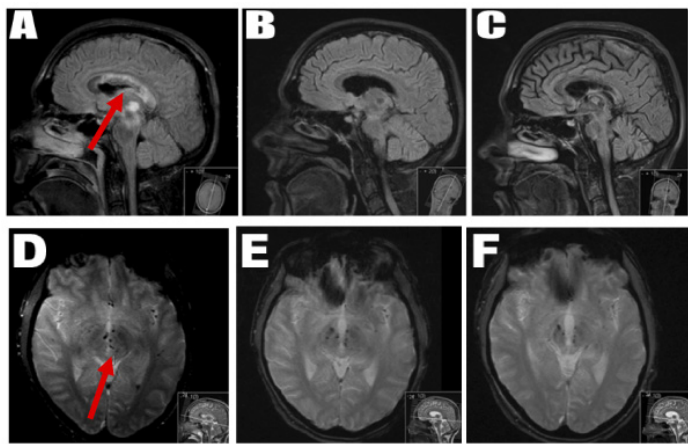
Figure A-C show sagittal midline FLAIR images of the same patient performed at three different time points (4 days, 3 months and 12 months). The first examination (A) shows lesions both in the corpus callosum, thalamus and the brain stem. At 3 and 12 months (B and C) these lesions have disappeared, but we find sequelae with atrophy. Figure D-E shows transverse T2\*GRE images of the same patient at the same time intervals. Multiple, bilateral haemorrhagic lesions are found in the brain stem that persist during the follow up period.
